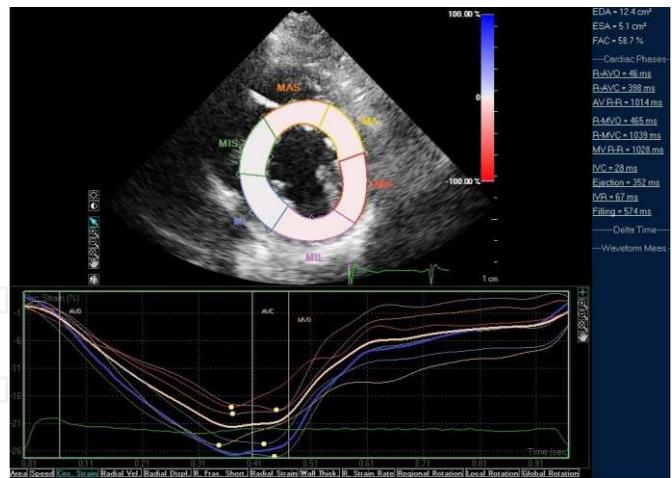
2D-speckle tracking analysis of circumferential strain from parasternal short axis view at the level of papillary muscles.
